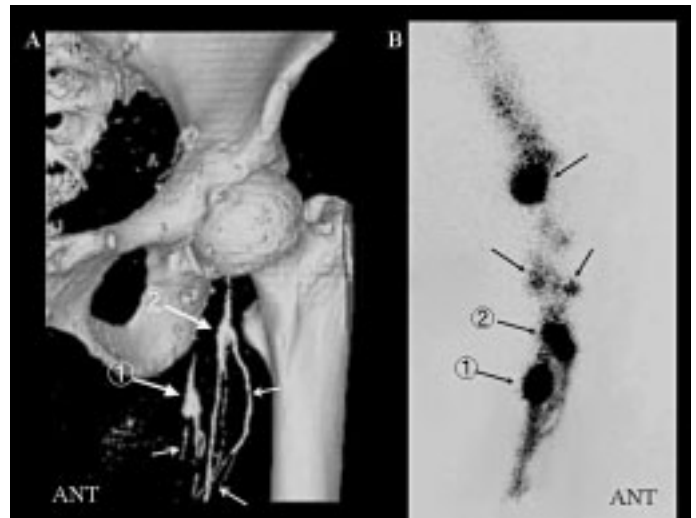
Surface-rendering 3D MIP MDCT-LG image (A), and Tc-99m-HAS lymphoscintigraphy (B) in a 54-year-old male with melanoma in the left foot (Patient No. 1 in Table 1).
